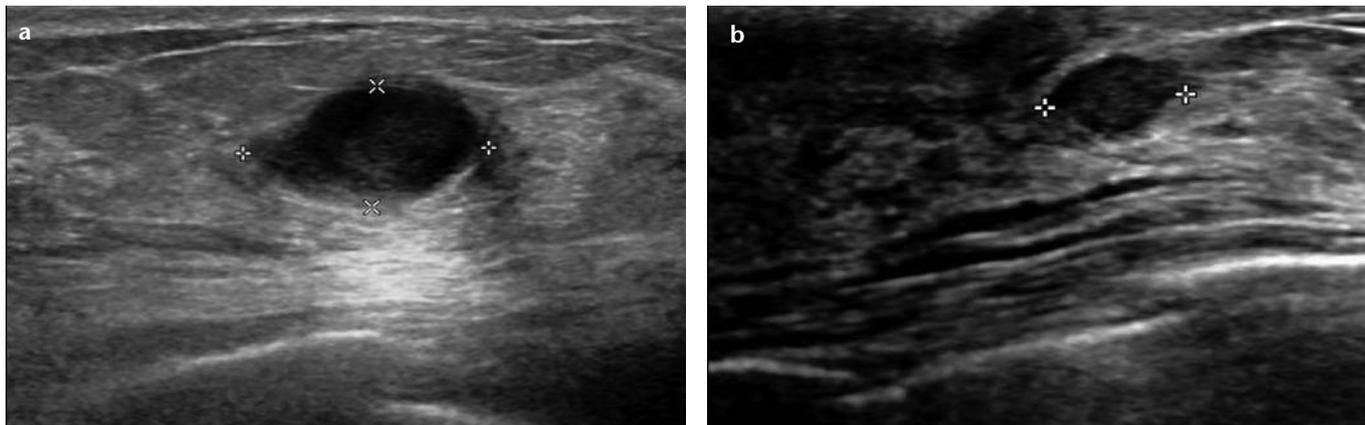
a, b. Mimics of papillary lesions. US (a) shows a cystic lesion with intracystic content; the cyst collapsed completely on fine-needle aspiration. Differentiating debris/clots and solid components within a cyst may be difficult, and demonstration of vascularity on Doppler imaging aids in establishing the solid nature. A biopsy-proven fibroadenoma is observed on US as a well-defined, ovoid hypoechoic retroareolar nodule that mimics a papillary lesion (b).
